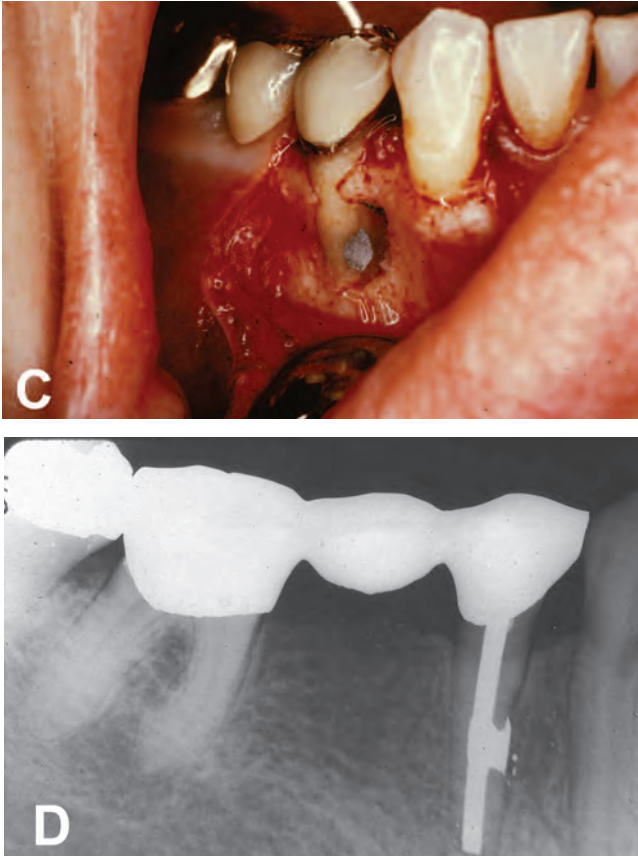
Continued. C, An amalgam filling is then placed in the resorptive defect. The silver point is removed, and the flap is sutured to place. Later a root canal filling and final occlusal restoration are placed. D, Radiograph taken 9 months later showing complete repair of the lateral bony lesion.
